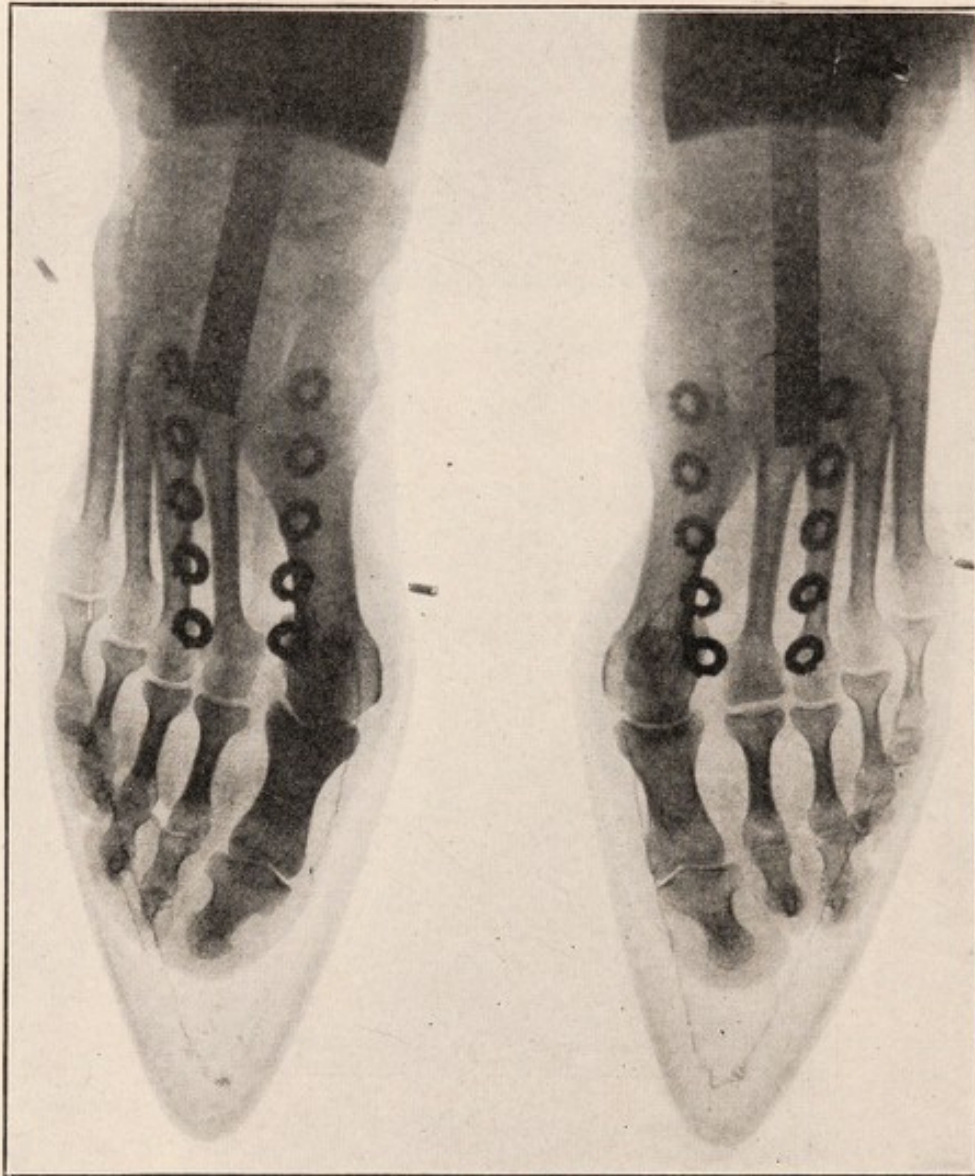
X-ray of Fig. 450 showing bone distortion.
